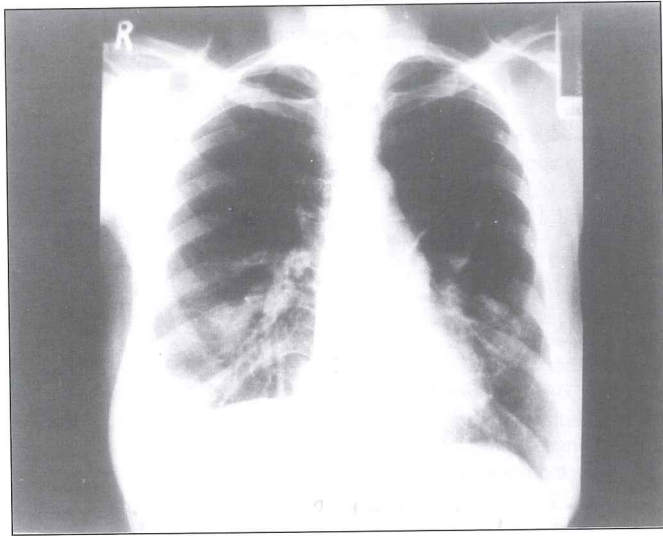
Bilateral patchy infiltrations in lung parenchyma (Postero-anterior chest X-ray).
